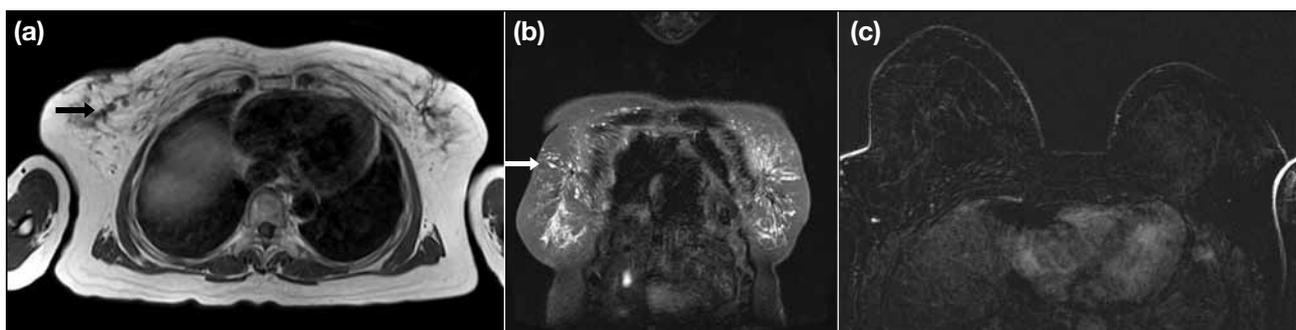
Bilateral breast augmentation by free injection of unknown materials. (a) An axial T1 image using a body coil showing multiple subcentimeter hyperintense foci representing injected materials in breast glandular tissue (arrow). (b) Coronal T2 turbo inversion recovery magnitude using the body coil demonstrates hyperintense foci representing injected materials (arrow). (c) A fully subtracted post-contrast axial T1-weighted image with breast dedicated coil does not show any tumour. The injected materials do not affect the accuracy of magnetic resonance imaging.
